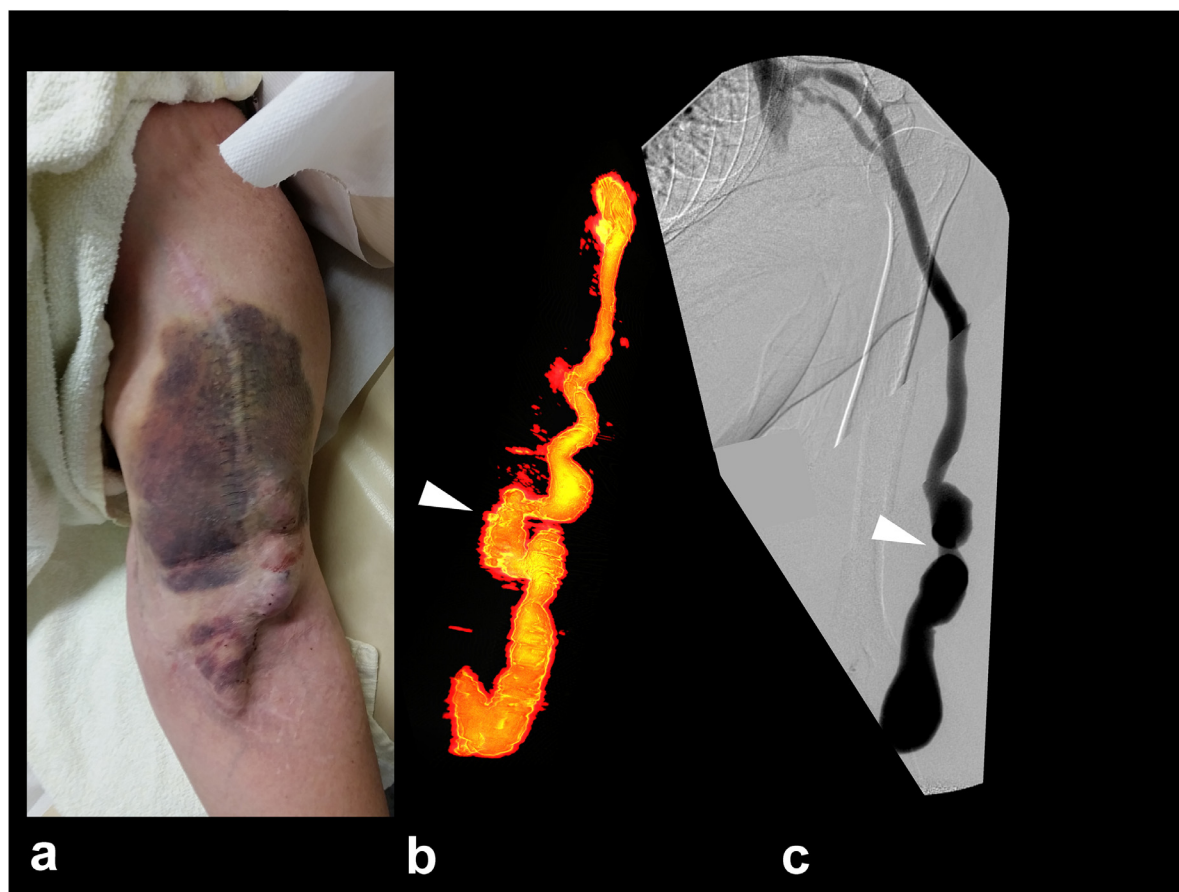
Comparison of photography, 3-D ultrasound and angiography of an aneurysmatic arteriovenous fistula. (a) Photography of the participant's arm with post-dialytic hematoma after misplaced cannulation. (b) 3-D tomographic ultrasound reveals the kinking between both aneurysms causing the misplacement of dialysis cannula (*arrowhead*). (c) Angiography of the aneurysmatic arteriovenous fistula in posterior-anterior view. Kinking is hidden in this projection (*arrowhead*).
